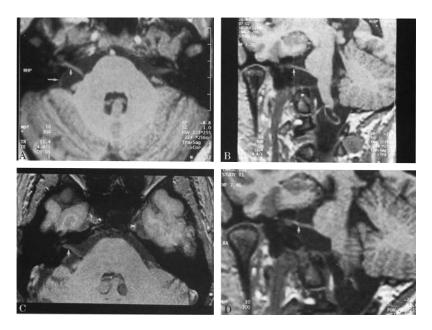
An arachnoid cyst in the region of the cerebellopontine angle. A, B T1-weighted magnetic resonance image before operation. The right vestibulocochlear nerve (*short arrow*) is displaced ventrally (A) and rostrally (B) by a cyst (*longer arrow* indicates its delimitation). C, D Postoperatively there is no longer any displacement and the patient is without complaints.
